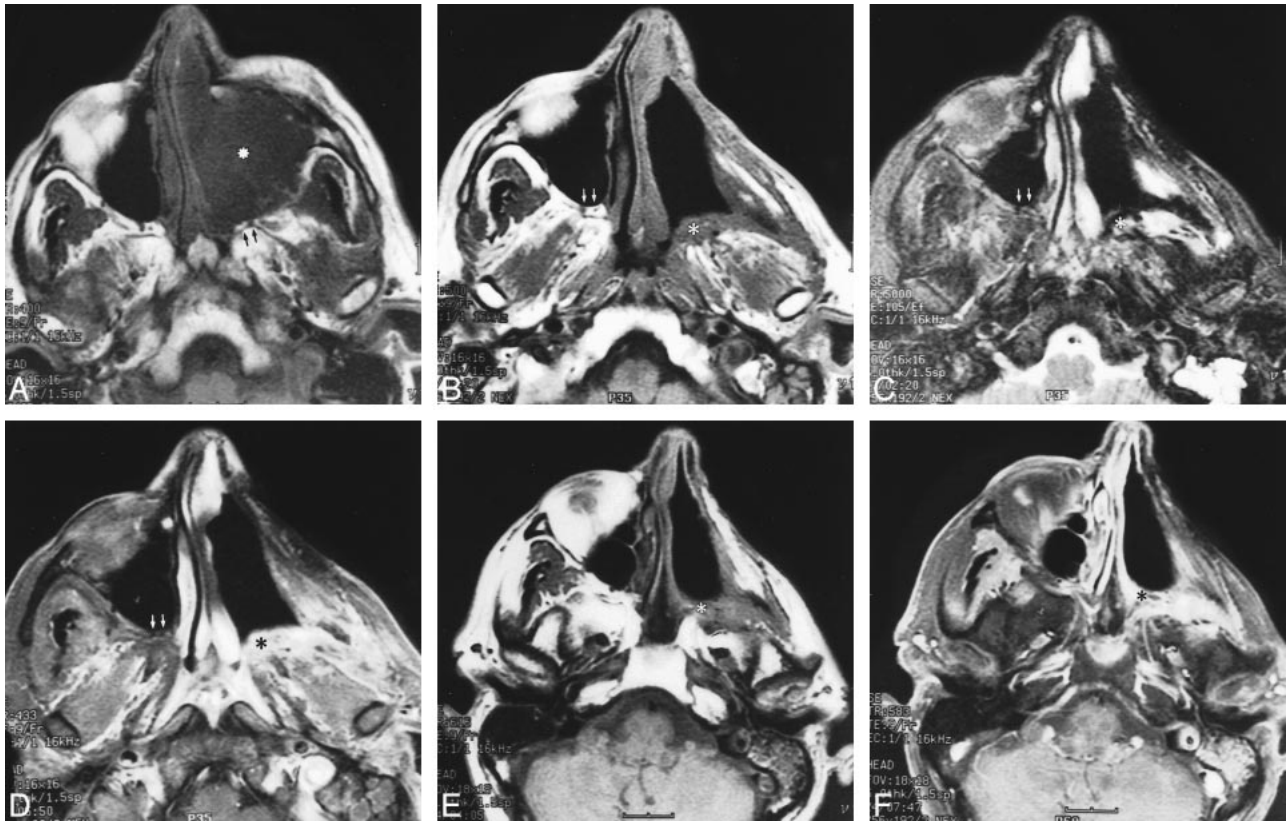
Axial MR images of a 55-year-old man with a left maxillary sinus malignant fibrous histiocytoma.
